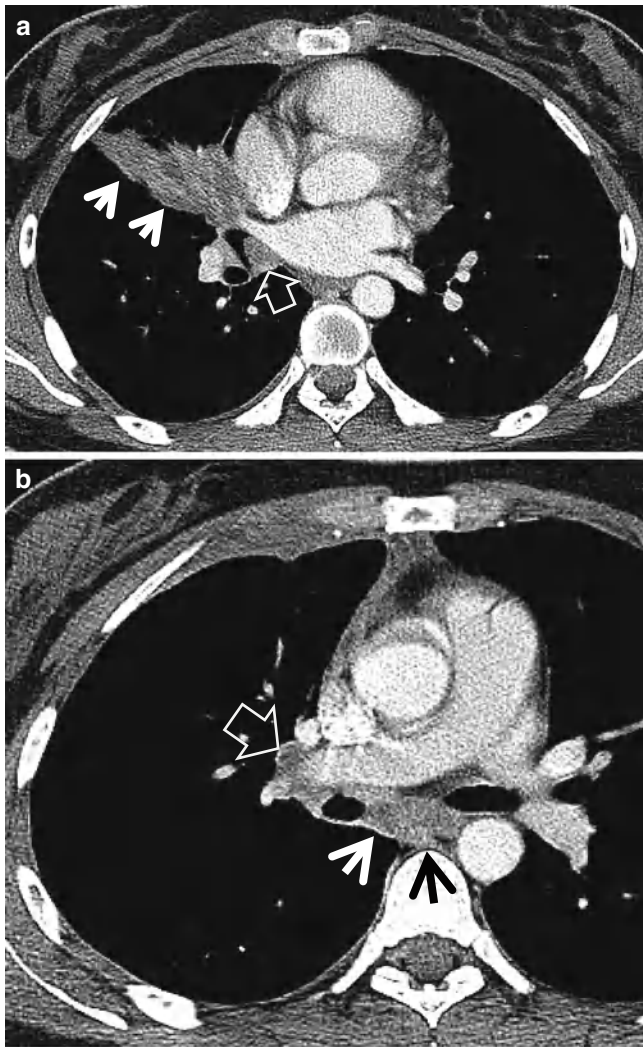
Tuberculous pneumonia manifesting as segmental consolidation in a 26-year-old woman. (a) Mediastinal window of enhanced CT scans (5.0-mm section thickness) obtained at level of basal trunk shows segmental consolidation (arrows) in right middle lobe. Also note enlarged right hilar lymph node (open arrow). (b) CT scan obtained at level of distal left main bronchus demonstrates enlarged and necrotic subcarinal lymph node (arrows) and right hilar node (open arrow)
